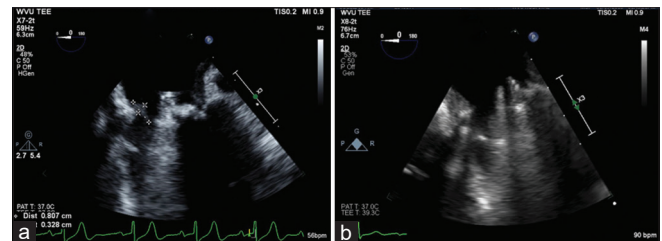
(a) Transesophageal echocardiogram done on initial admission shows vegetation on the medial aspect of the annulus of mechanical mitral valve. (b) Transesophageal echocardiogram done on final admission which is negative for any vegetation
